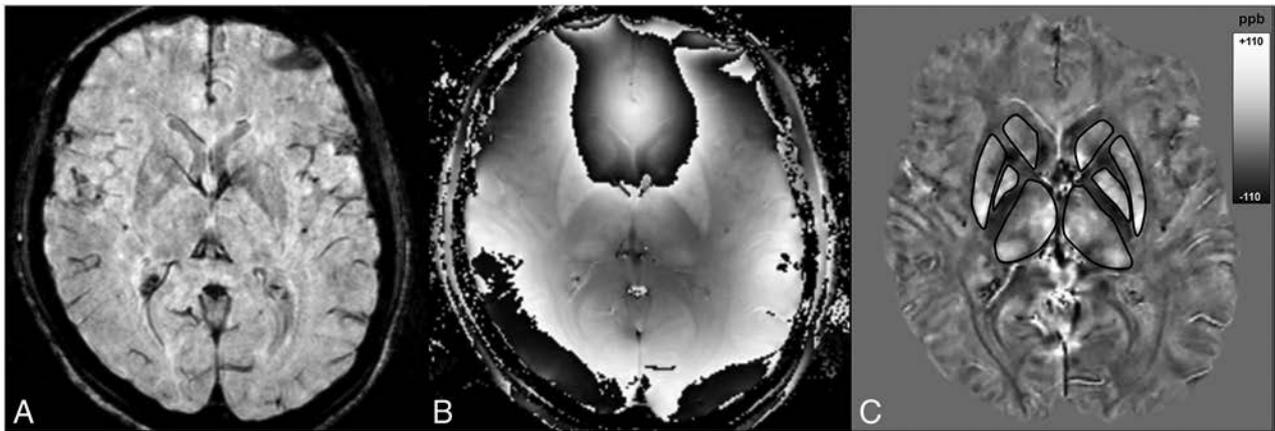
Sample MR image section depicting gradient-echo magnitude (A), raw phase (B), and quantitative susceptibility map (C) with ROIs outlined in the caudate nucleus, putamen, globus pallidus, and thalamus.
